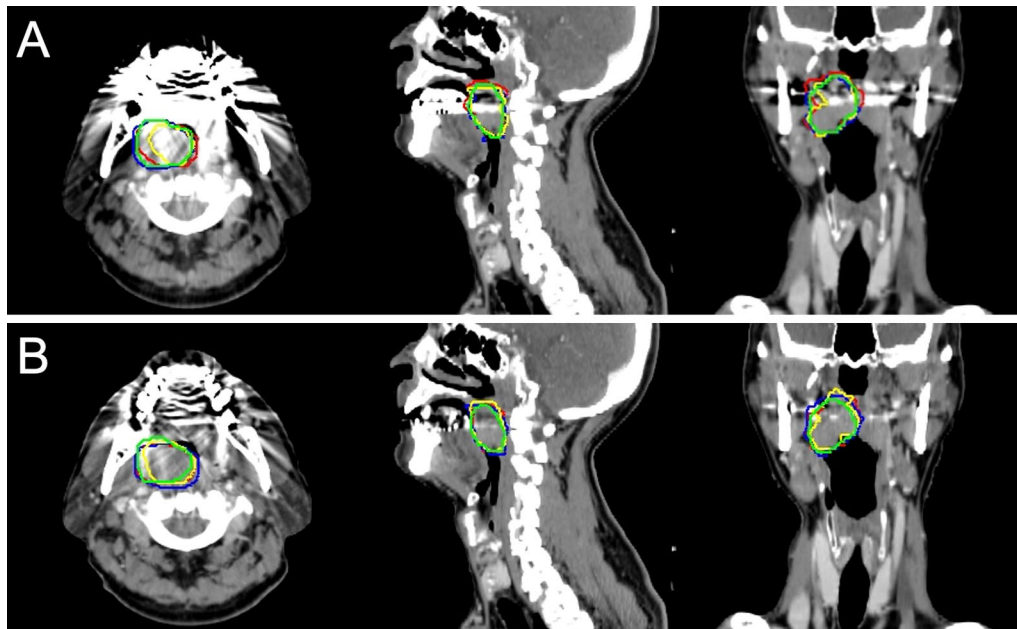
Examples of gross tumor volume (GTV) in patients with tonsillar cancer. Each panel includes axial (left), sagittal (center), and coronal (right) images. A GTVs were delineated by four observers using conventional computed tomography (CT) images. The mean Dice similarity coefficient (DSC) was 0.80 with a mean GTV value of 23.7 cm³. B GTVs were delineated by four observers based on conventional and metal artifact reduction fused CT images. The mean DSC improved to 0.83 with a mean GTV value of 21.6 cm³ based on the combination of conventional and metal artifact reduction CT images
